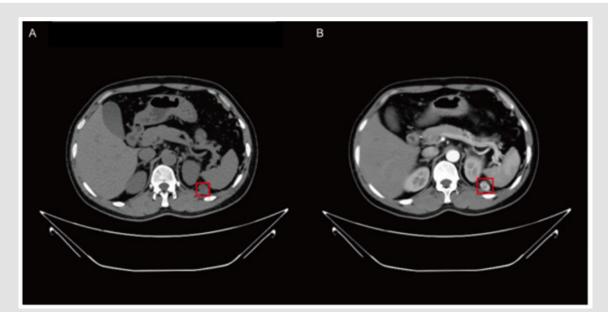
In the transverse plane of non-contrast enhanced CT and contrast-enhanced CT, periphrenal intradipose metastases were significantly strengthened and isolated from the kidney.
